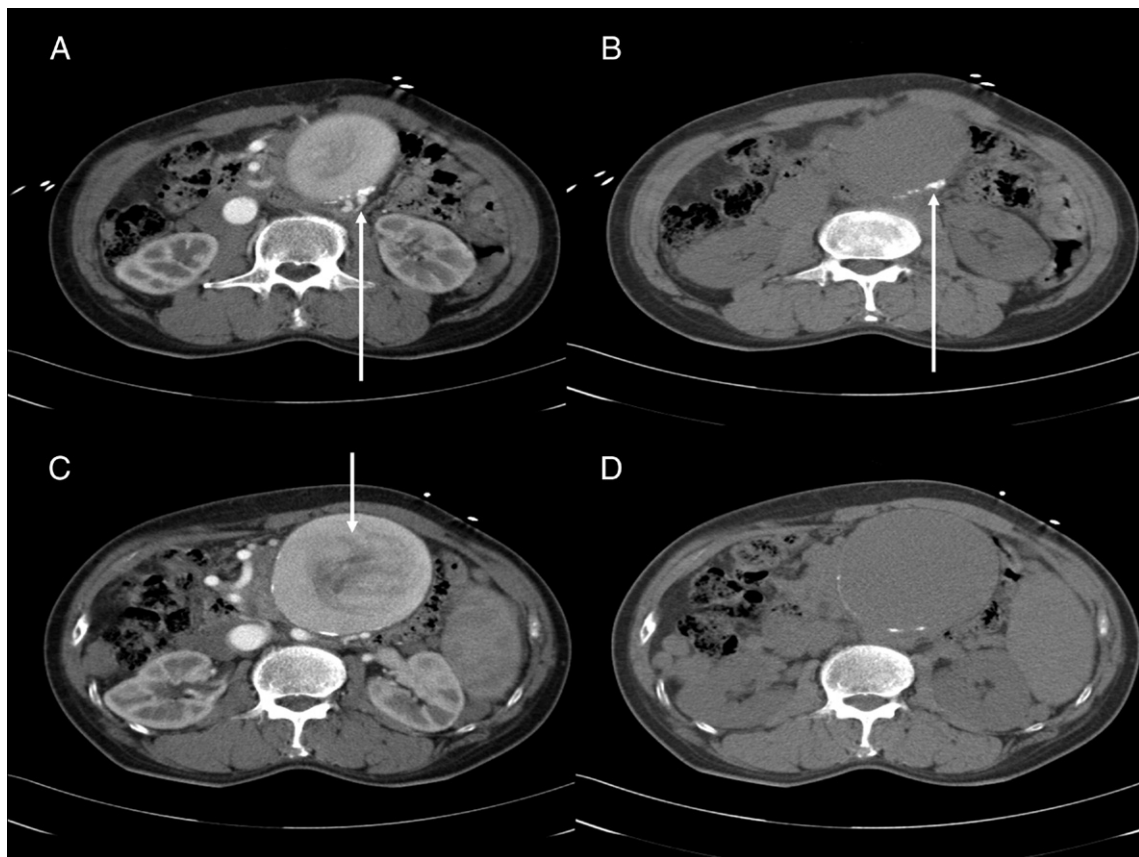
Abdominal CT scan shows 9.3×8.9 cm-sized mass with wall continuity to calcified (upward arrow) SMA at mid abdomen renal hilum level. This lesion shows internal whirling enhancement and contrast jet (downward arrow).
